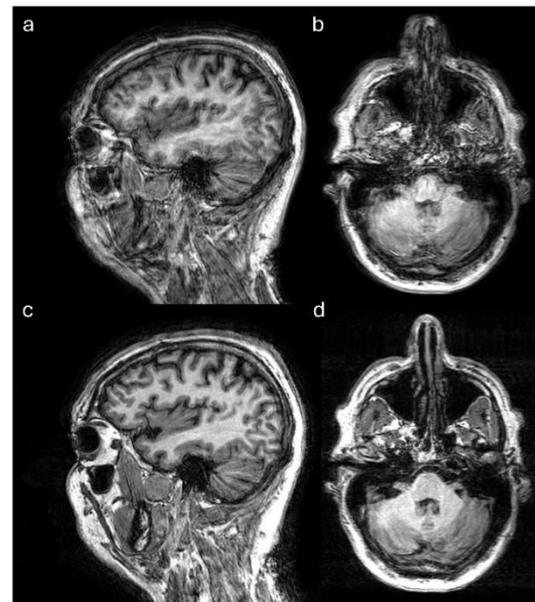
T1-weighted 3D IR-TFE scan of subject with medium sized pose changes during scan. (a/b) Non-corrected standard reconstruction. (c/d) RMC reconstruction shows substantial improvement in image quality, most tangible in the realignment of the nasal septum.
